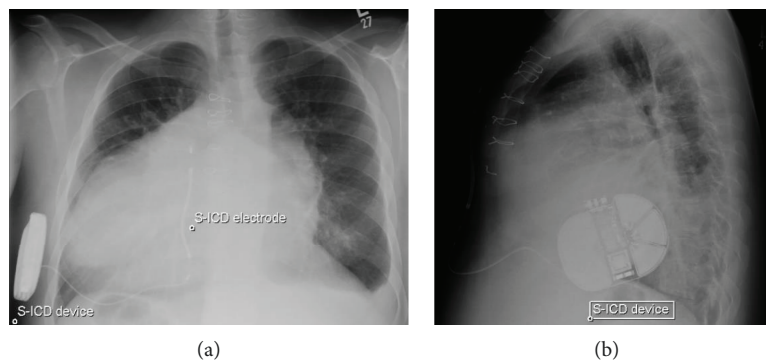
Posteroanterior (a) and lateral (b) chest x-rays showing situs inversus totalis, pectus excavatum, sternal wires from previous cardiac surgeries, and the S-ICD device and electrode. Note the presence of cardiomegaly, small left pleural effusion, and basilar atelectasis. S-ICD: subcutaneous implantable cardioverter defibrillator.
